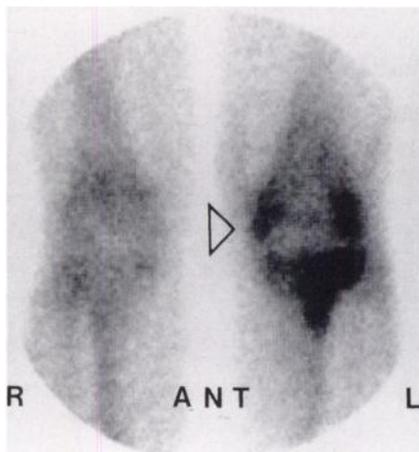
Patient 12. Anterior bone scintigraphy demonstrates a large intense lesion in the left lateral tibial plateau which was confirmed on MRI. The less intense lesion in the lateral femoral condyle was not seen on MRI. The faint but definite focal uptake peripherally in the medial femoral condyle (arrow head) was an avulsion of the insertion of the medial collateral ligament on MRI and confirmed at surgery. The classic triad of avulsion of the medial collateral ligament with opposite "kissing" lesions laterally is obvious on scintigraphy. Knowledge of this type of injury facilitates scintigraphic interpretation, however, avulsion injuries could be misinterpreted as fractures.
